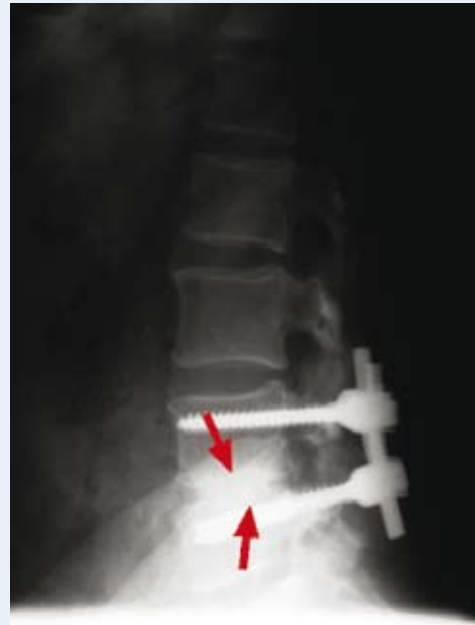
b) Quality and continuity of fusion are seen in direct lumbar radiography
